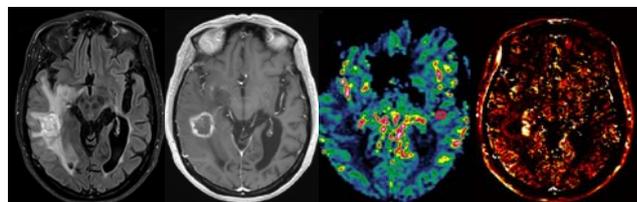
T2-FLAIR weighted image, contrast-enhanced T1-weighted image, and rCBV and IAUC colour maps obtained from a right temporal TDL. Observe the ring enhancing lesion in the subcortical white matter with extensive edema mimicking a high grade glioma, which shows low rCBV and IAUC
